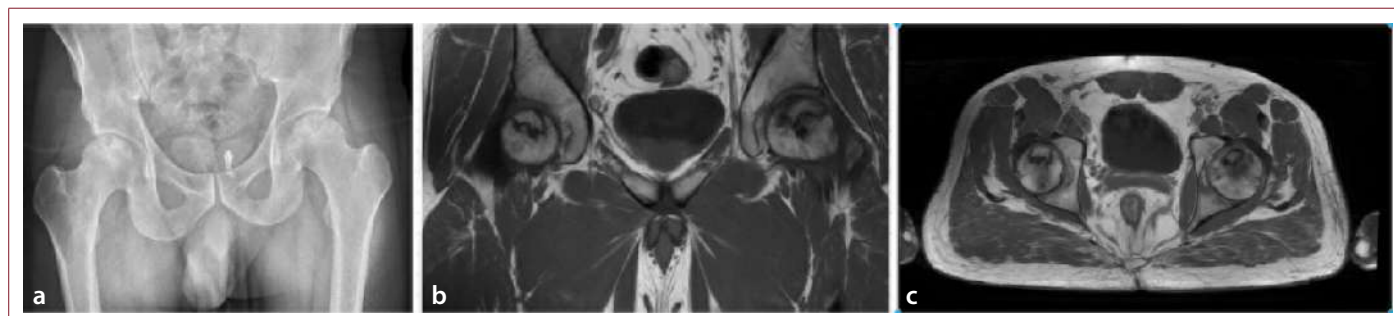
X-ray (a) and MRI (b,c) images of a 52-year-old male patient presenting with bilateral hip pain due to prior corticosteroid use. (a) X-ray demonstrated bilateral mixed sclerosis and cystic areas. (b) T1-weighted coronal and (c) T1-weighted axial slices showing well-defined anterosuperior lesions, indicating ONFH.
